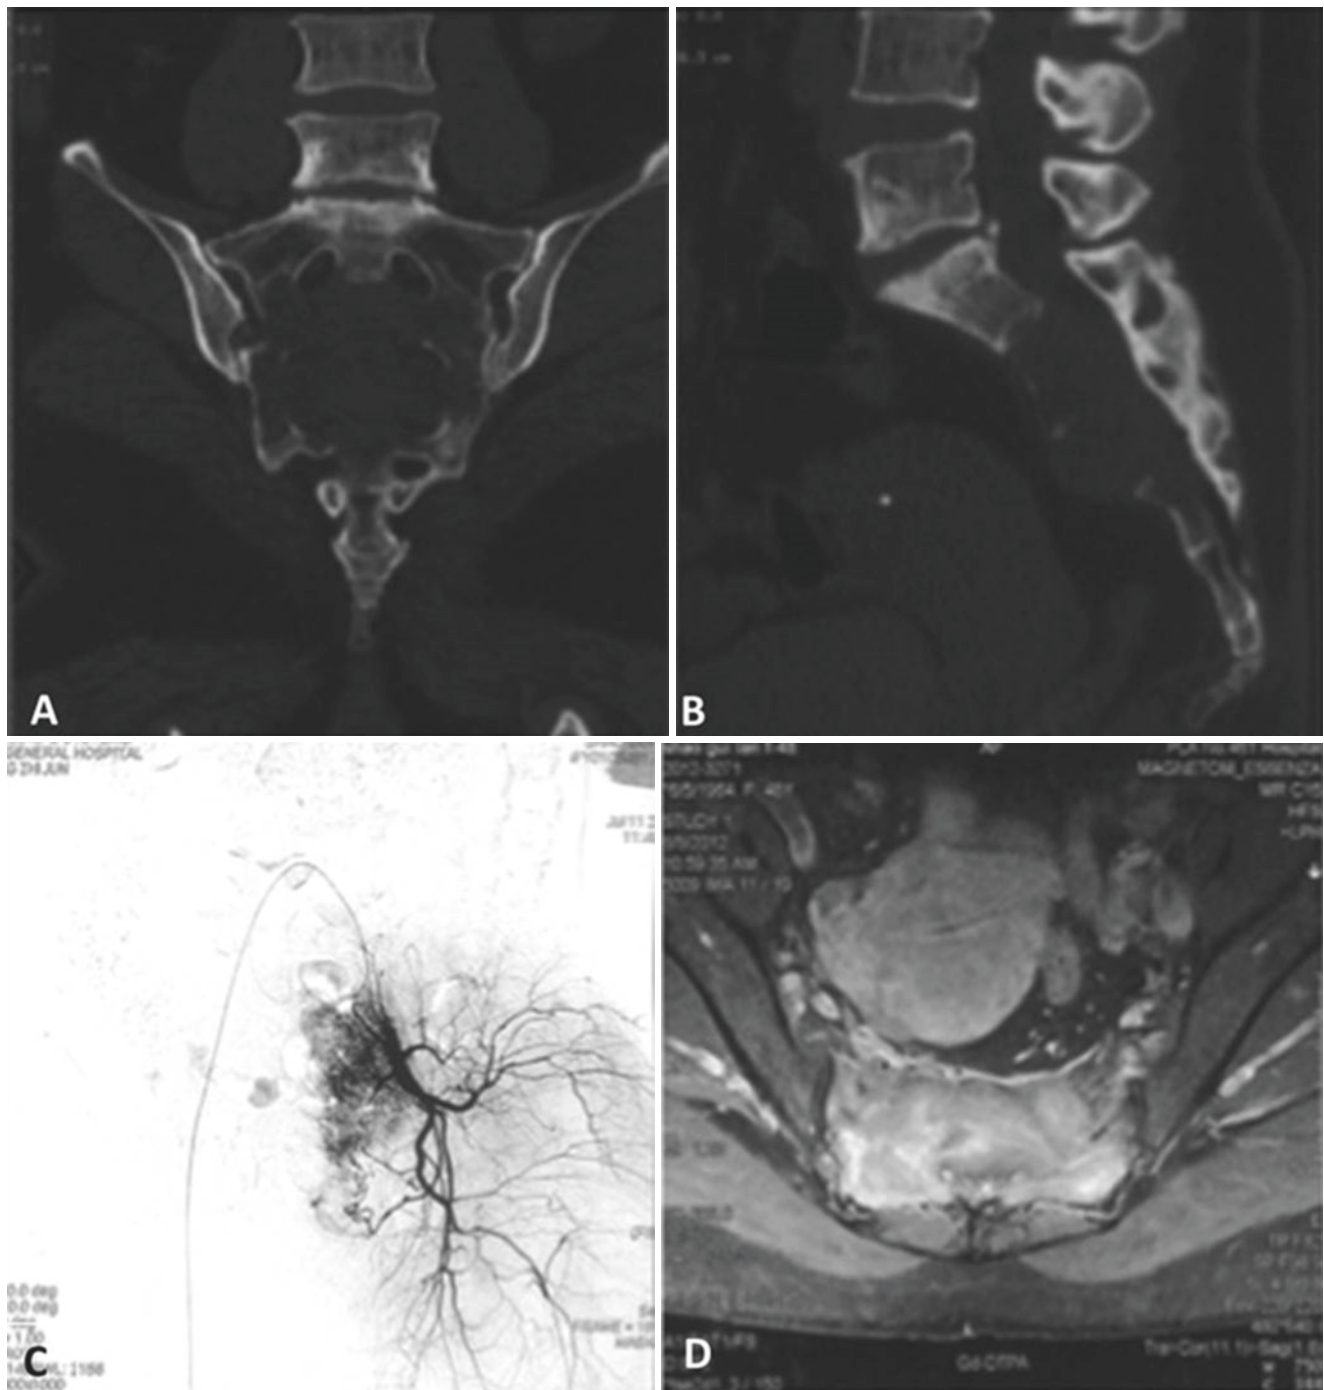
The radiographs of a 48-year-old female patient with sacral giant cell tumor who presented with lumbosacral analgesia for nearly 1 year. (a–c) showed the CT and MRI manifestation of tumor. (c) Digital subtraction angiography showed the hypervascularity of this
